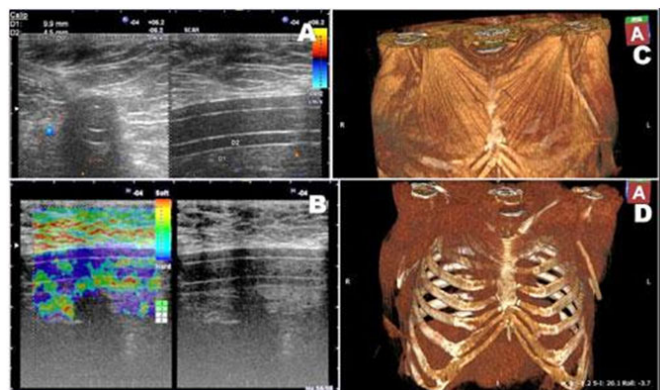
Other case, 60-year-old patient, 5 years after the radical modified mastectomy Madden for BC: FBU depicted a “forgotten” drain tube with the upper pole under the great pectoral muscle, persistent after oncological treatment and radiotherapy, with local tissue tolerance, but a slight functional muscular disturbance of the ipsilateral upper limb (A, B); the multidetector CT with VR confirmed the diagnosis (C, D).
